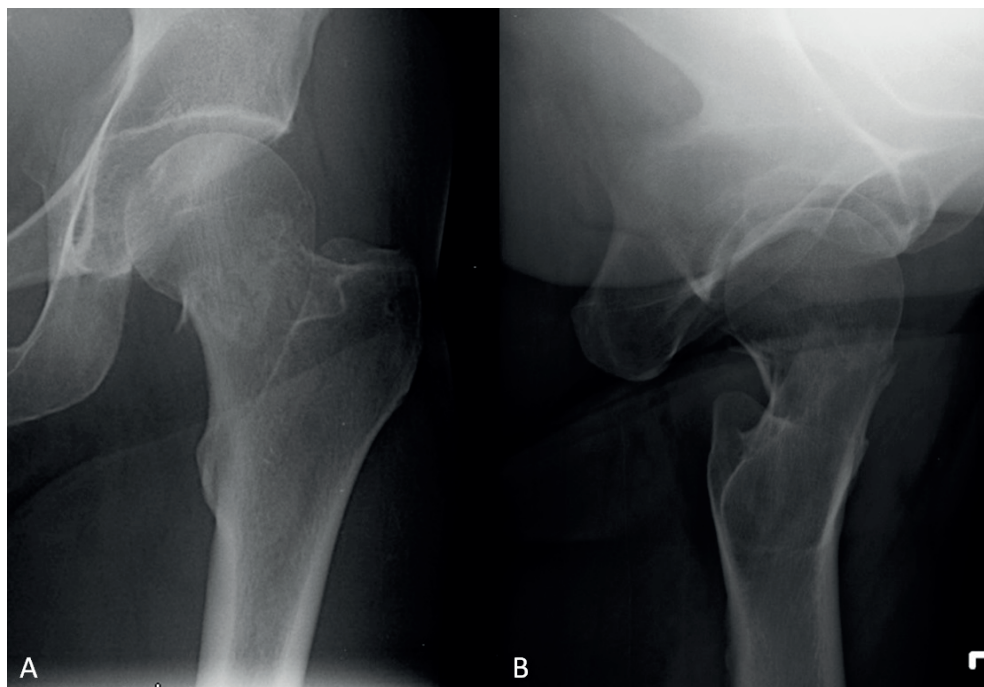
A: Anteriorposterior radiograph of a ‘non-displaced’ FNF. B: Lateral radiograph of a FNF with posterior tilt of the femoral head and comminution of the posterior cortex.
